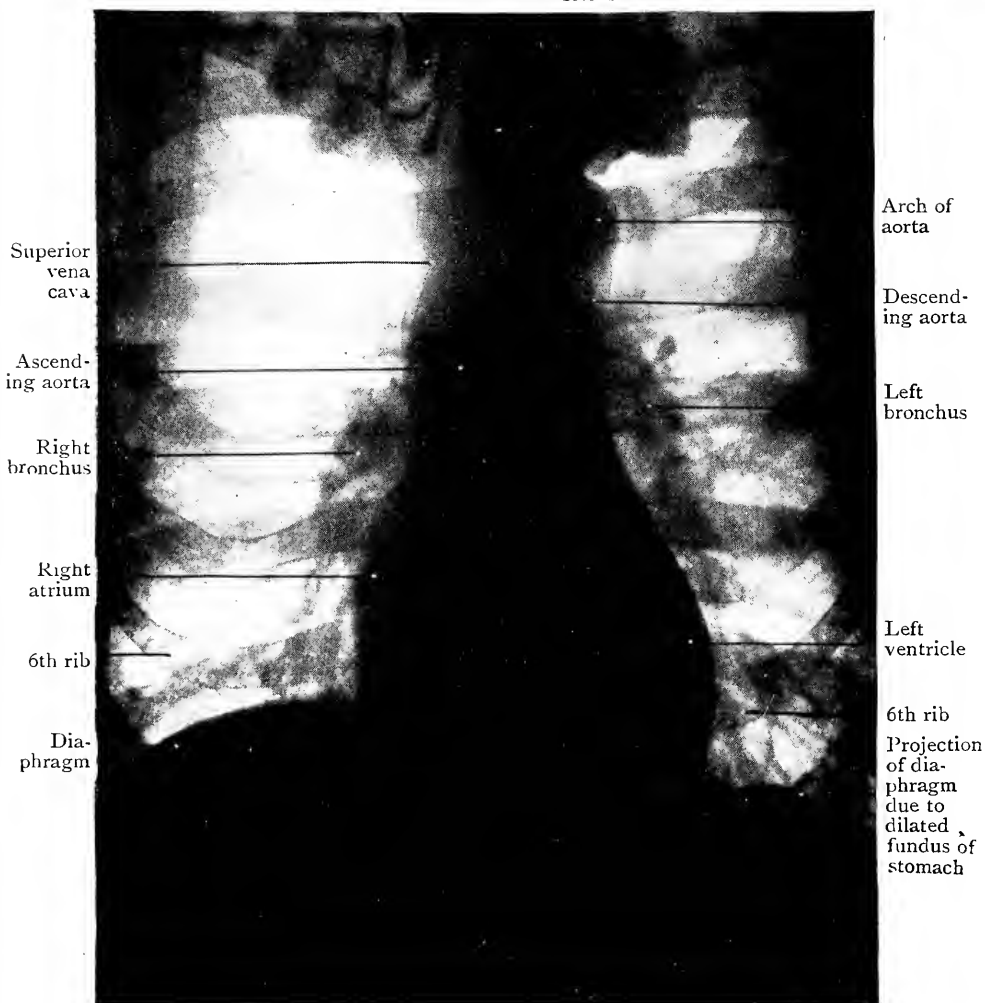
Radiograph of Thorax in expiration, showing the positions of the heart, the great vessels and the bronchi.
